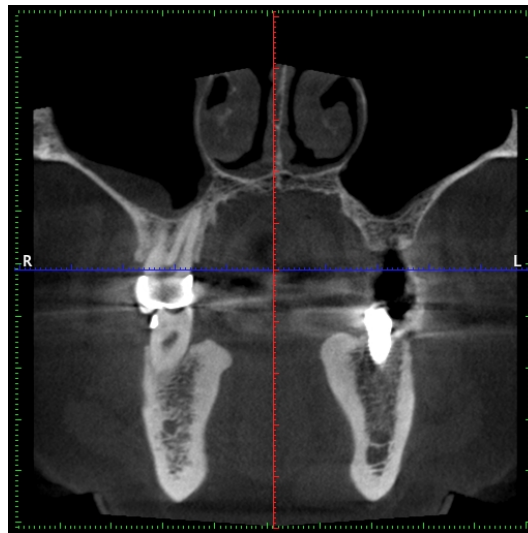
CBCT scan from a periodontitis patient (left) and detailed view of a trabecular bone from that scan where it can be identified the fractal nature of periodontal tissues.
